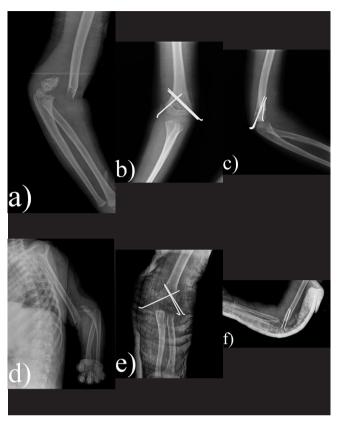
Pre- and post-operative radiographic images of patients with Gartland extension type III supracondylar humerus fractures. (a, b, c, d, e, f)
